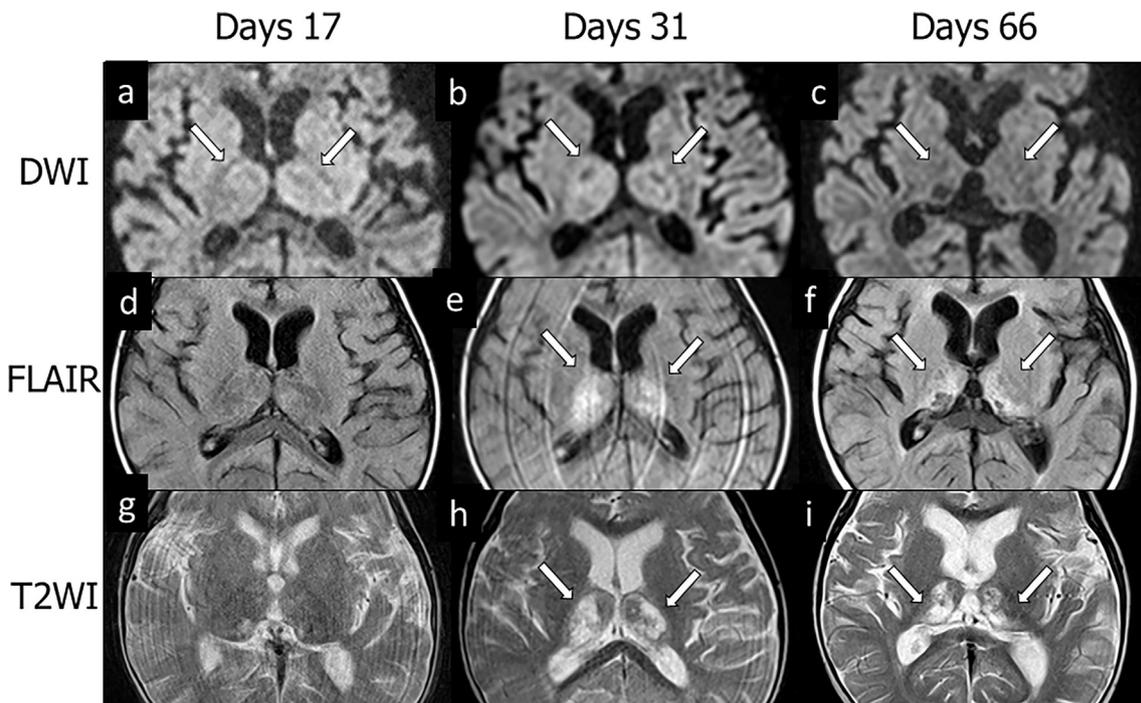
Brain MRI in the chronic phase. Brain MRI revealed changes in the thalamus, from swelling to atrophy with cavitation on DWI on days 17 (a), 31 (b), and 66 (c), on FLAIR on days 17 (d), 31 (e), and 66 (f), and on T2-weighted images on days 17 (g), 31 (h), and 66 (i). Thalamic lesions are indicated by arrows. Abbreviations: MRI: magnetic resonance imaging, DWI: diffusion weighted imaging, FLAIR: fluid-attenuated inversion recovery.
